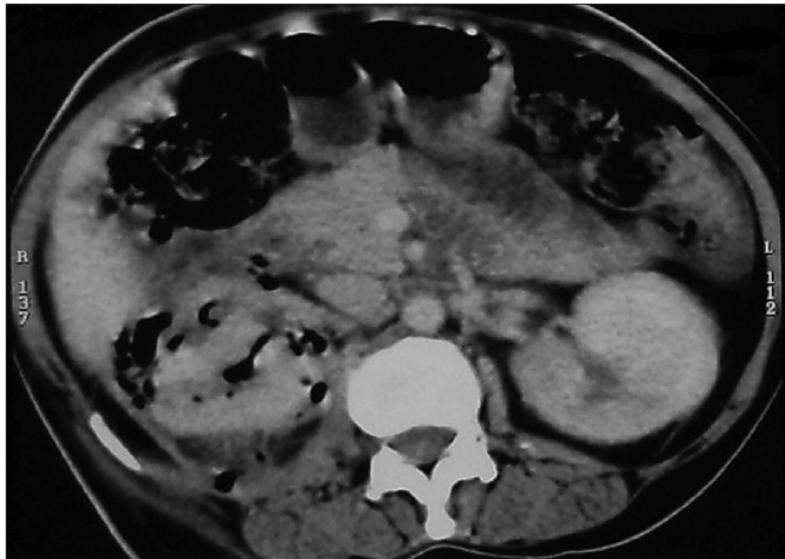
CT KUB Class 3B EPN
